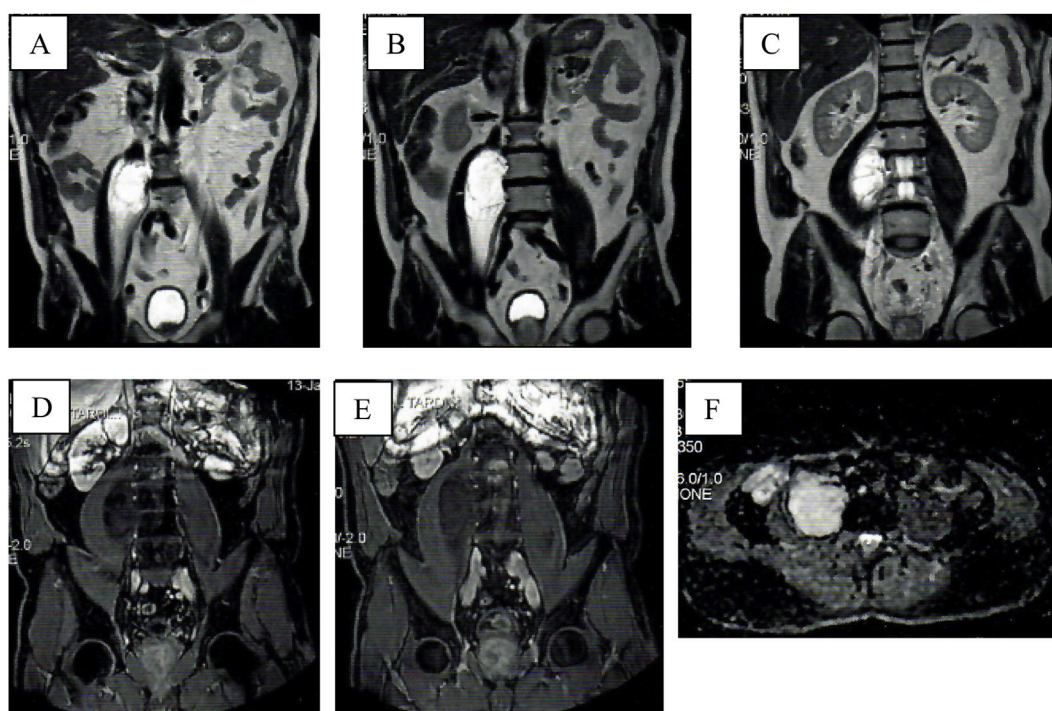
Pelvic MRI: (A–C) hyperintense lesion in T2 without fat suppression, well delimited and interior septa; (D and E) T1 sequences with fat suppression and contrast, limited enhancement, slow but progressive; (F) no restriction of diffusion.
